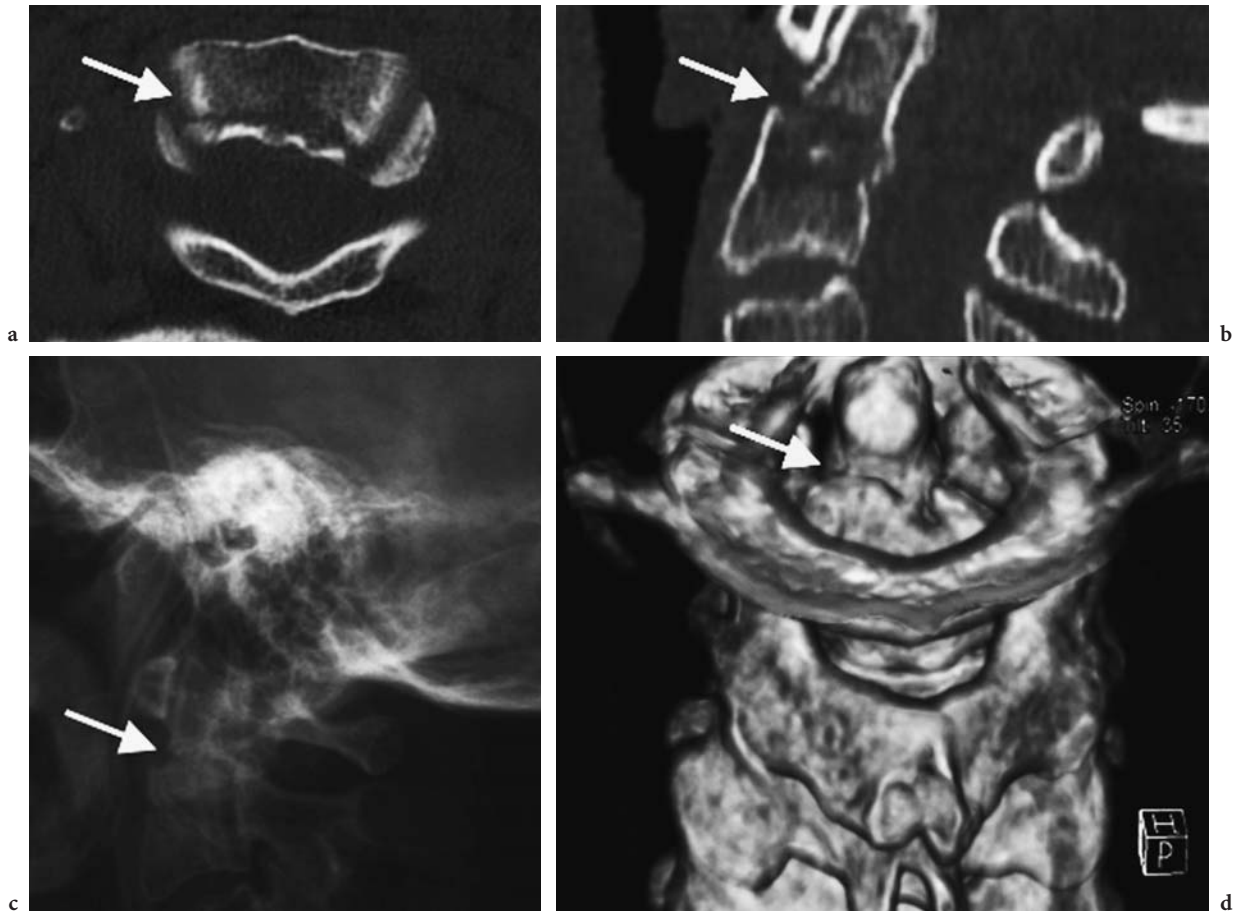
Odontoid fracture: type II. a Axial CT image. b Sagittal CT reformation. c Lateral view radiograph. d CT, volume rendering. Coronal, posterior view
